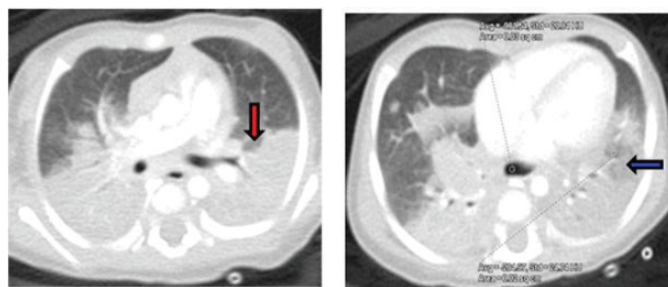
CT scan showing necrotizing pneumonia with cavitory lesions suggestive of progressive tuberculosis with lymph node and lung involvement. The CT scan also showed bilateral lower lobe consolidation with areas of low attenuation (red arrow) having an average Hounsfield unit of -205 relative to air, and $HU = -982$ (blue arrow).
